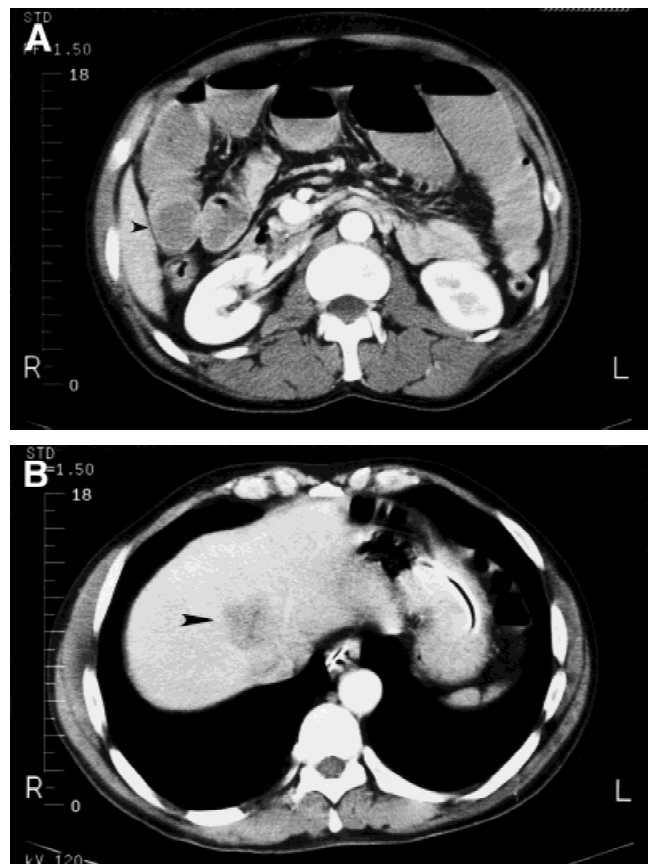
A: Computed tomographic (CT) scan with evidence of small bowel obstruction and a mass in the ascending colon. B: CT scan showing metastatic tumor in the liver.
